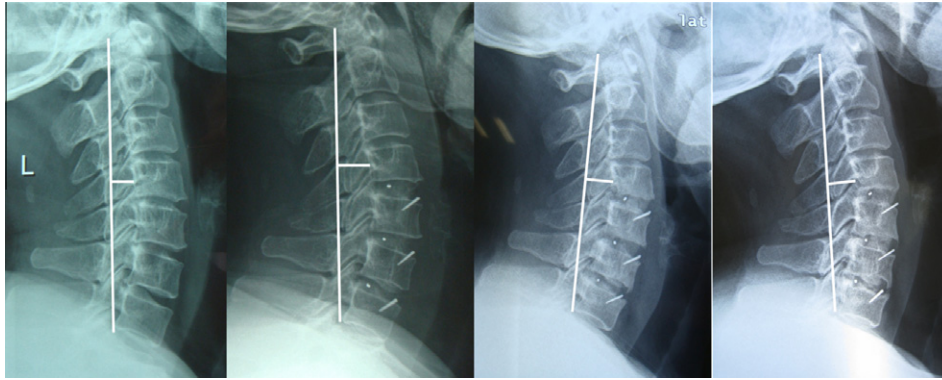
Lateral radiographs (A) preoperative; (B) postoperative; (C) 6 months after surgery; and (D) at the final follow-up showing the spinal curve changes of a patient with C5–C7 myelopathy who underwent anterior discectomy and fusion with polyetheretherketone stand-alone cages.
